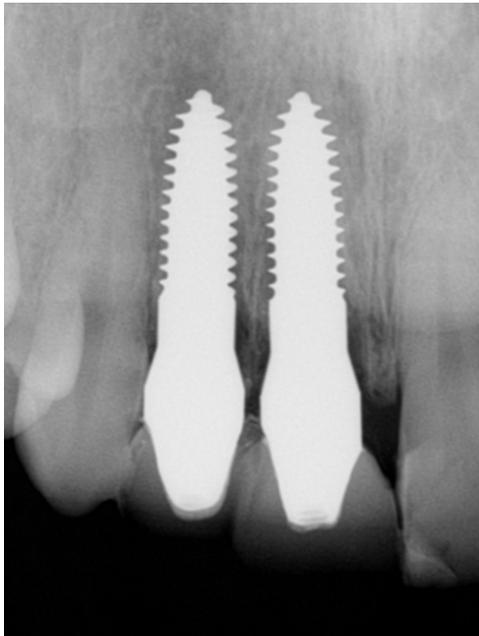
Postoperative x-rays with temps in place.
